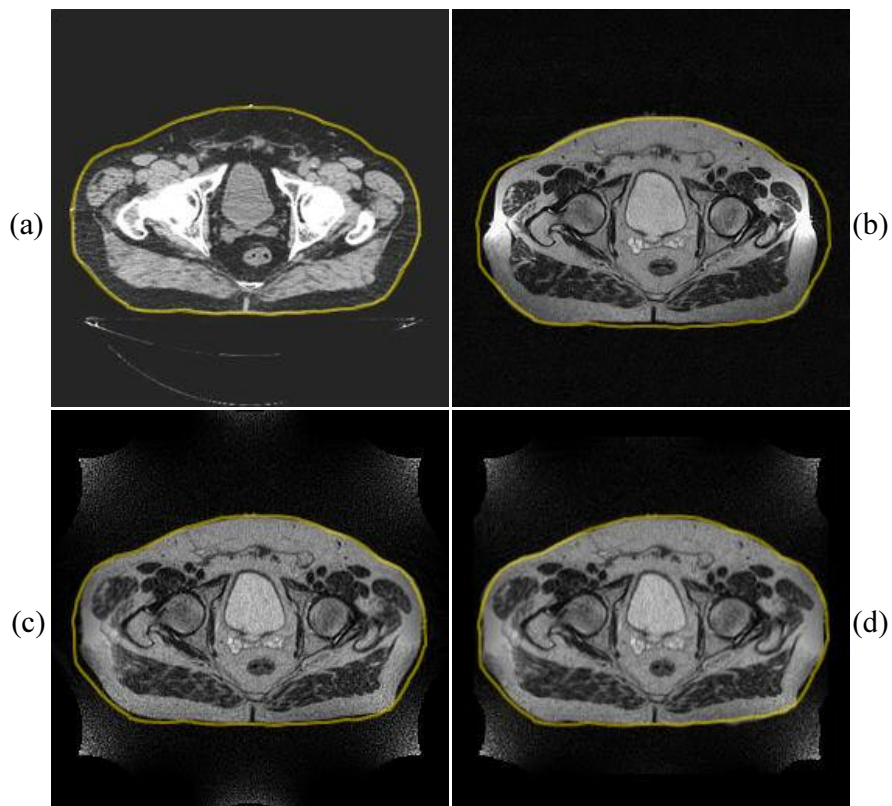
CT and MR images of a prostate patient: (a) a distortion-free CT image, b) the same patient imaged on the MR scanner without any distortion corrections, c) only with the GDC post-processing, and d) with both the GDC and our point-by-point correction. The external contours on the MR images were exported from the CT image after image fusion.
